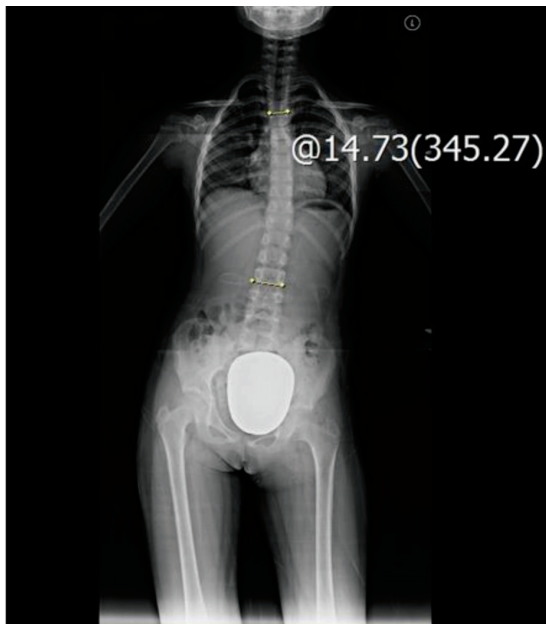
Whole spine x-ray (July 14, 2015). The image shows scoliosis of the thoracolumbar spine curvature (left side) and 14.73° Cobb angle.
